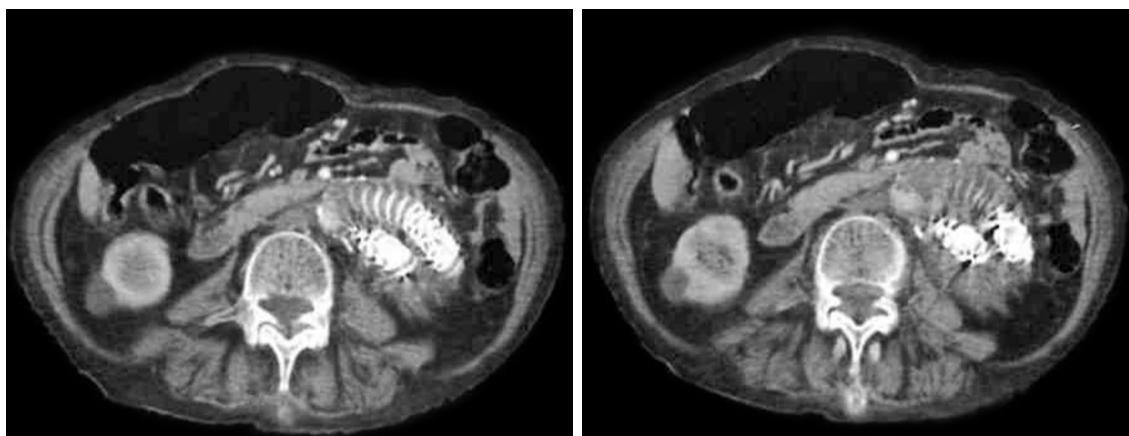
Sequential CTA images obtained in the axial plane showing contrast filling close to the distal part of graft consistent with type 1B endoleak (No. 6).
